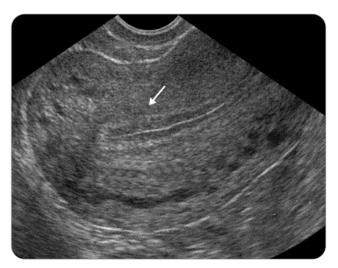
Ultrasound showing triple layered appearance of endometrium
